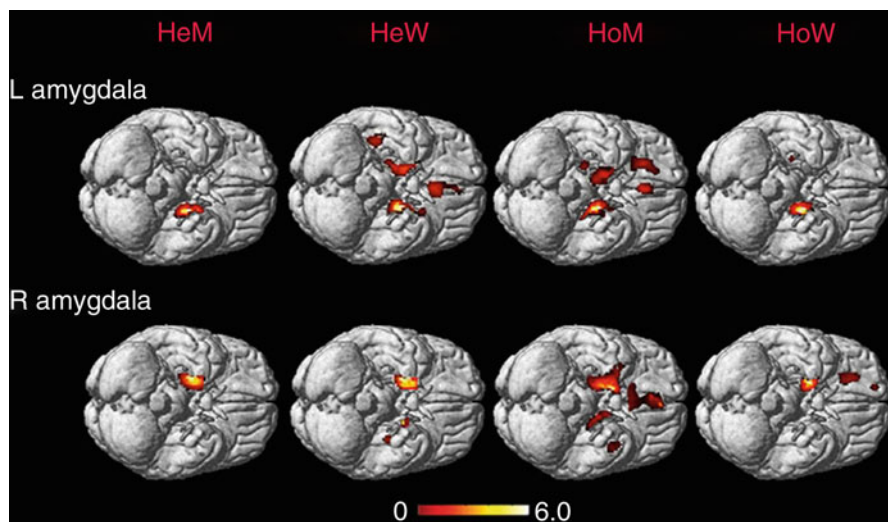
Covariations with the respective amygdala seed region in hetero- and homosexual subjects. The Sokoloff scale indicates T values. Clusters detected at $T = 3.0$ are superimposed on the standard magnetic resonance image of the brain. In homosexual men (HoM), like in heterosexual women (HeW), the connections were more widespread from the *left* amygdale, in homosexual women (HoW) and heterosexual men (HeM), on the other hand, from the *right* amygdala. Furthermore, in HoM and HeW, the connections were primarily displayed with the contralateral amygdale and the anterior cingulate, in HeM and HoW with the caudate, putamen, and the prefrontal cortex (From Savic and Lindstrom 2008, Fig. 1, © The National Academy of Sciences of the United States of America)
